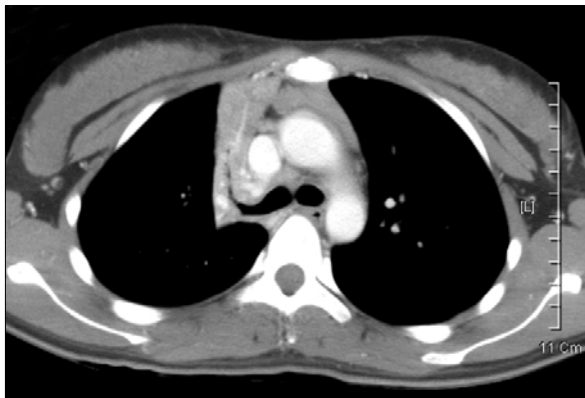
Chest CT shows total collapse of right upper lobe.
